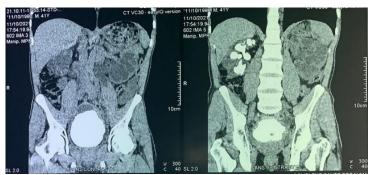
Frontal CT scan: bilateral renal dilation with large right staghorn calculus and cortical thinning, giant calculus occupying almost the entire bladder
